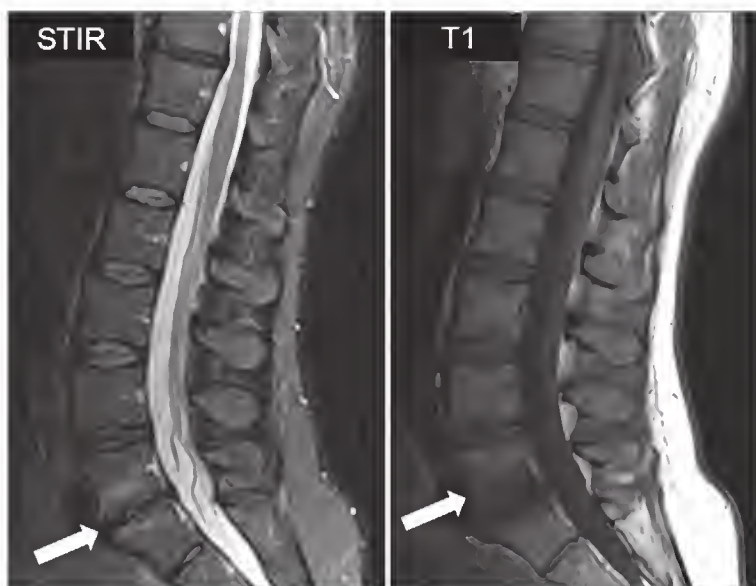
Modic 1 lesion (arrows) characterized by bone marrow edema in the area of the vertebral endplates on short tau inversion recovery (STIR) magnetic resonance image and by hypointense signal on T1-weighted image, accompanied by a decrease in disk height and degeneration of the intervertebral disk.
